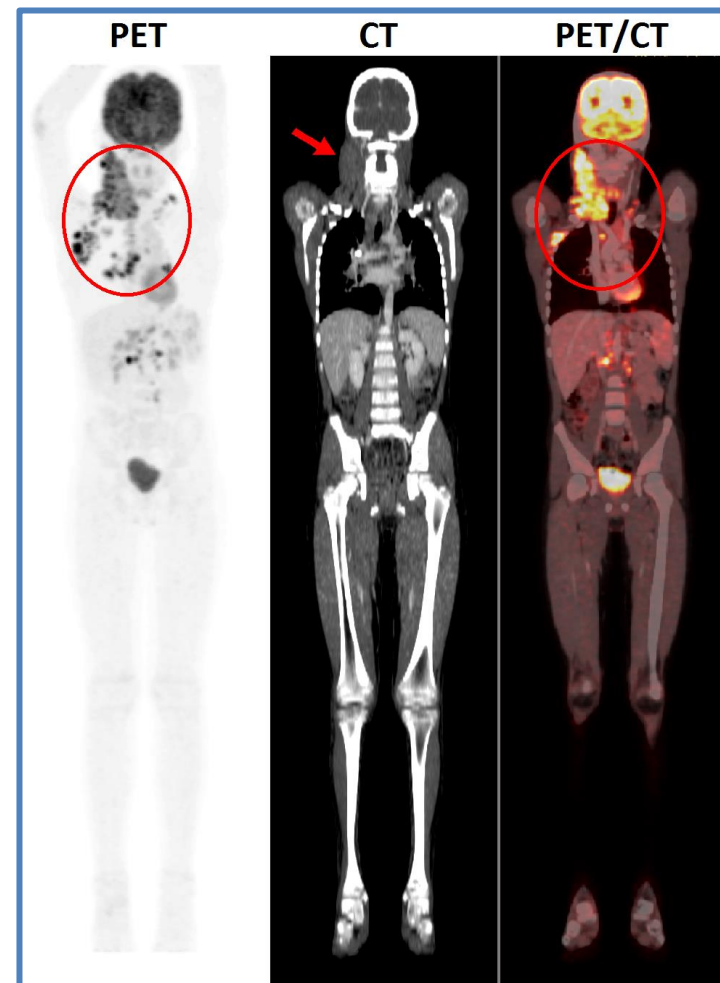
PET, CT, and PET/CT scans performed on a pediatric patient with lymphoma. Areas of malignancy are indicated by a circle or red arrow.
